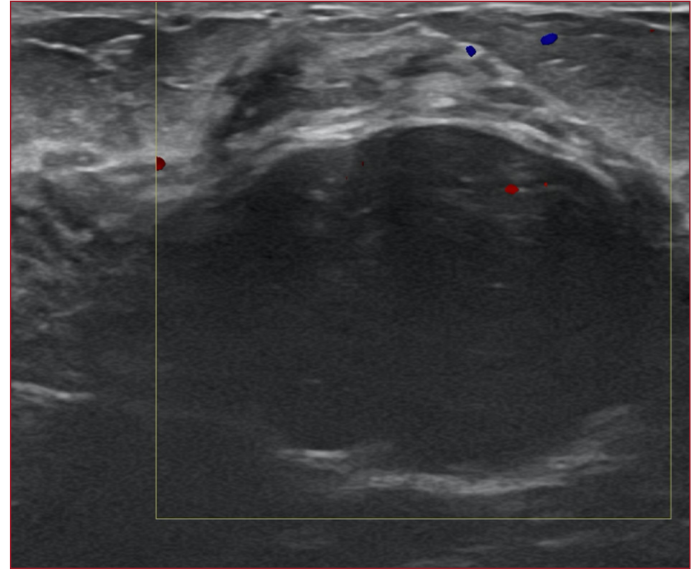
38y/o patient who presented with a palpable circumscribed oval solid mass with minimal vascularity on color doppler US image.
